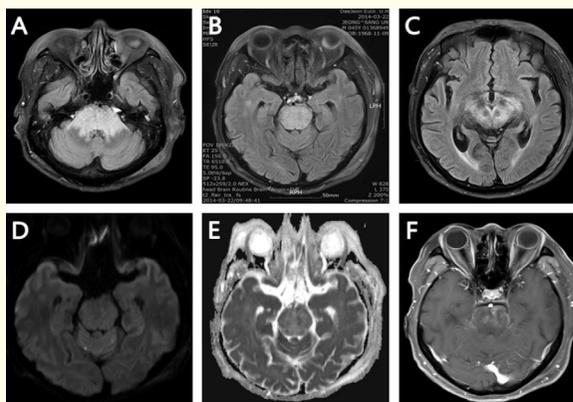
Initial MRI of patient. Fluid-attenuated inversion recovery (FLAIR) image both revealed symmetrical hyperintensities at whole midbrain, pons and cerebellar peduncle symmetrically (A, B, C). Diffusion-weighted imaging (DWI) showed low intensity at the same areas, while apparent diffusion coefficient (ADC) mapping showed high intensity (D, E). Focal enhanced lesion in T1 contrast image at same area. These findings indicated vasogenic edema (F).
